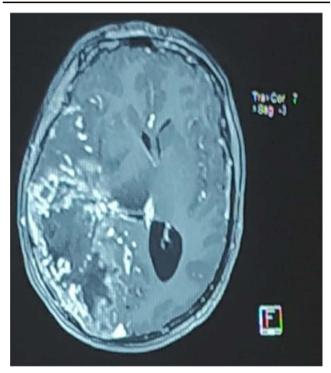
Brain MRI noting a hypervascularized right intra-axial parieto-temporo-occipital tumor process of probable glial origin or an associated arteriovenous malformation.
